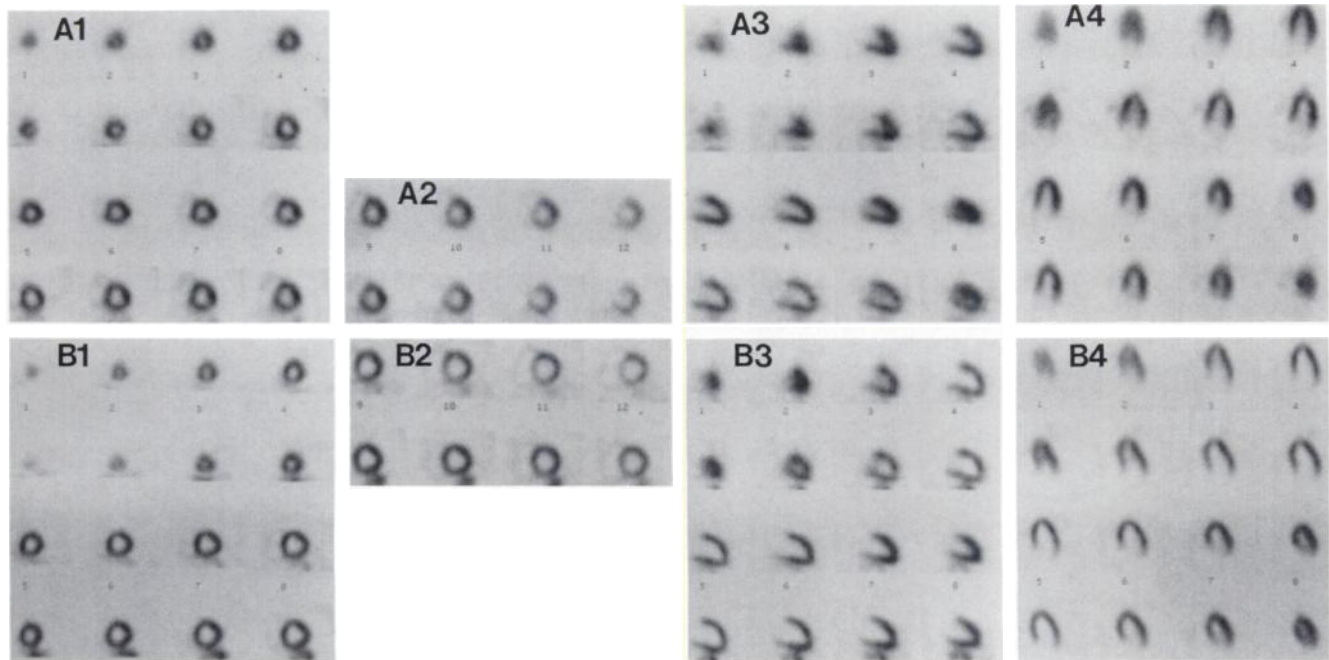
Normal SPECT myocardial perfusion images obtained with ^{201}Tl (A) and $^{99\text{m}}\text{Tc}$ -sestamibi (B). Sestamibi images were acquired and processed using parameters outlined in the text and Tables 2 and 3. Stress and 4-hr delayed or resting images are paired for each tomographic slide with the stress images immediately above the corresponding delayed or resting images. Six millimeter thick short-axis slices are shown in A-1 and A-2 for ^{201}Tl and B-1 and B-2 for $^{99\text{m}}\text{Tc}$ -sestamibi, proceeding from the apex to the base (1-12) of the left ventricle. Vertical long-axis slices are shown in A-3 and B-3, proceeding from the lateral wall to the septum (1-8). Horizontal long-axis slices are shown in A-4 and B-4, proceeding from the anterior to the inferior wall.
